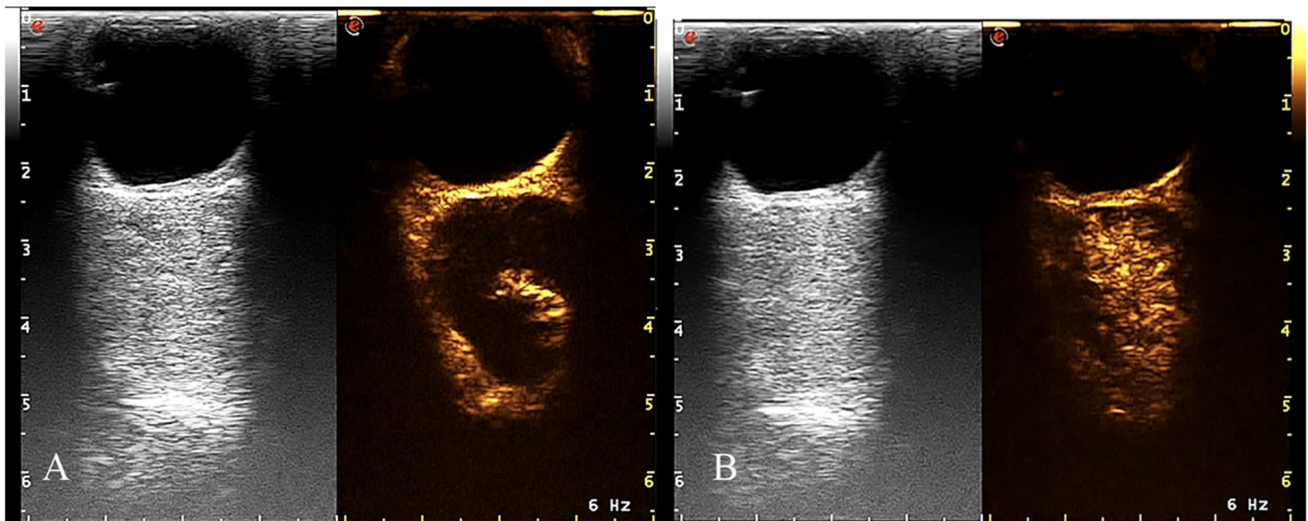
Diffuse enhancement pattern of orbital cavernous venous malformation in a 33-year-old female patient with cavernous malformation. (A) The lesions show no typical nodular enhancement in 14 sec. (B) The lesions show overall heterogeneous enhancement in 22 sec. The gray image is a conventional ultrasound image and the gold image is a contrast-enhanced ultrasound image.
